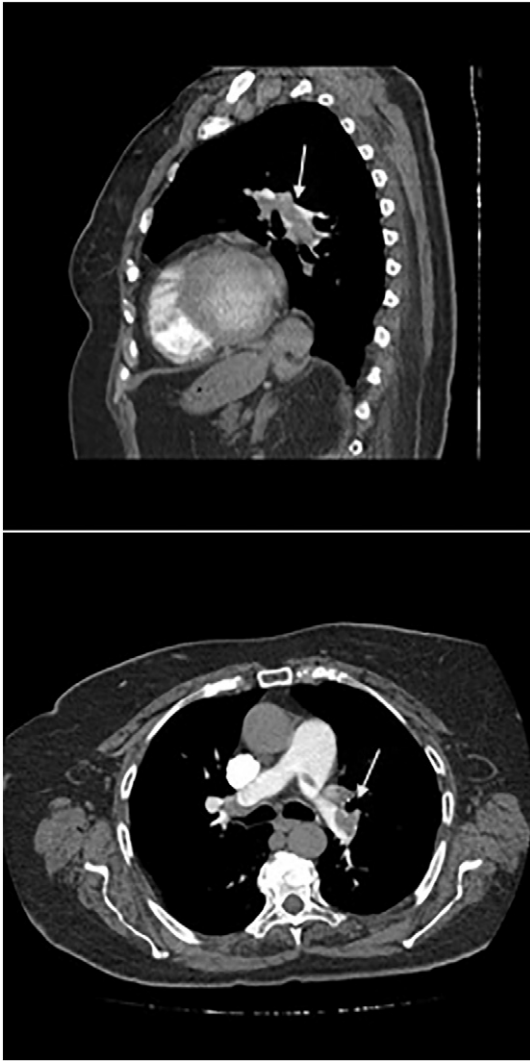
Computed Tomography shows pulmonary embolism.
